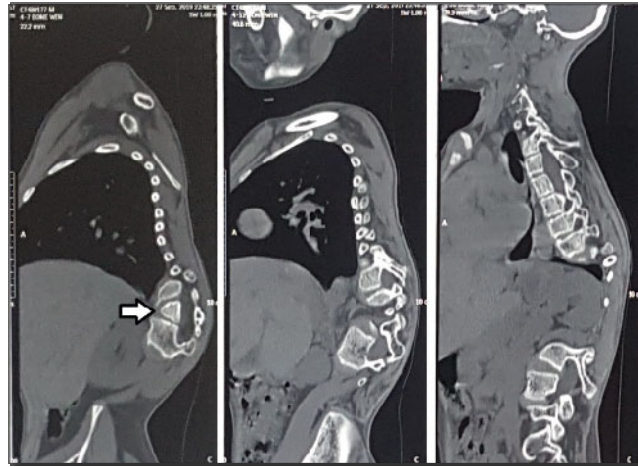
Preoperative serial CT scans (sagittal view) of spine showing kyphoscoliotic deformity with right sided convexity (arrow pointing towards D12 hemivertebra). Note the vertebral dysplasia and malalignment.
